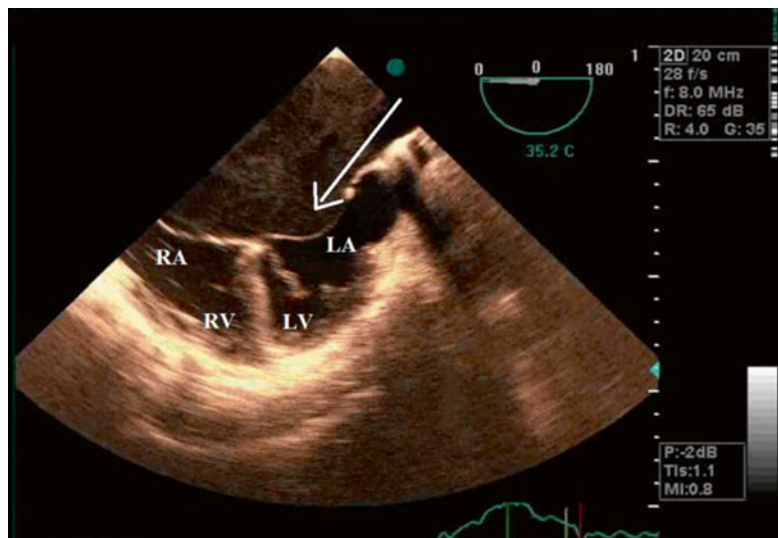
Transesophageal echocardiography in 4-chamber view showing cor triatriatum with a small opening and significant smoky pattern (Videos 50.3 and 50.4). LA left atrium, RA right atrium, LV left ventricle, RV right ventricle
